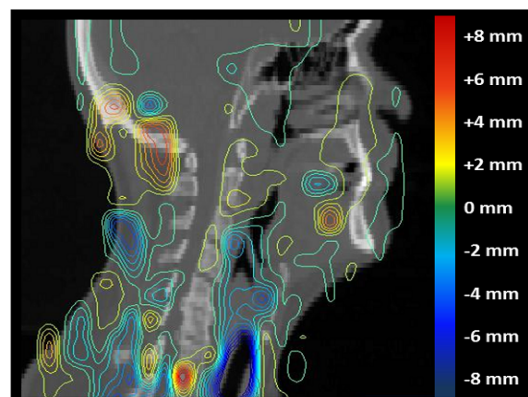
Sup-Inf axis error map (colour scale: +8 to -8 mm) determined by BMI method, following registration error analysis of diagnostic position H&N MR with RT planning CT for a clinical patient registration. Large errors are present in the oesophagus due to swallowing. The registration around the posterior skull base is poor, due to limitations of the registration process.
